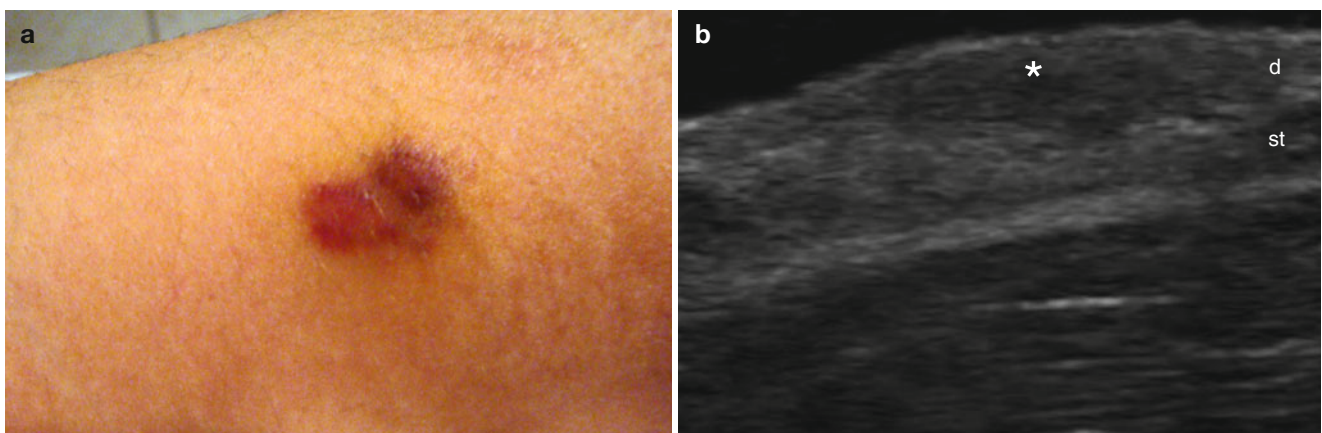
(a–f) Kaposi's sarcoma. (a) Clinical reddish lesion in the inner aspect of the left arm (HIV positive patient). (b) Grey scale ultrasound (longitudinal view) shows ill-defined, focal hypoechoic thickening (*) that involves the dermis and upper subcutaneous tissue. There is increased echogenicity of the lower subcutaneous tissue. (c) Power
